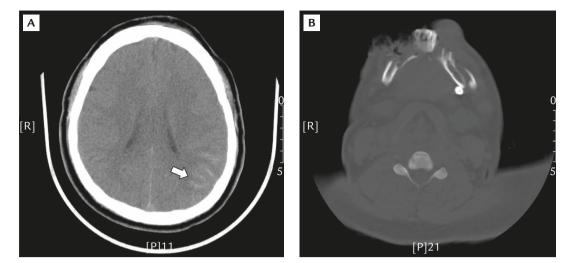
Computed tomography showed: (A) mild swelling of the brain and limited subarachnoid hemorrhage at the left parieto-occipital lobes (white arrow), and slight compression of the left lateral ventricle by brain edema; (B) compound comminuted mandible fracture with severe facial tissue lacerations.
